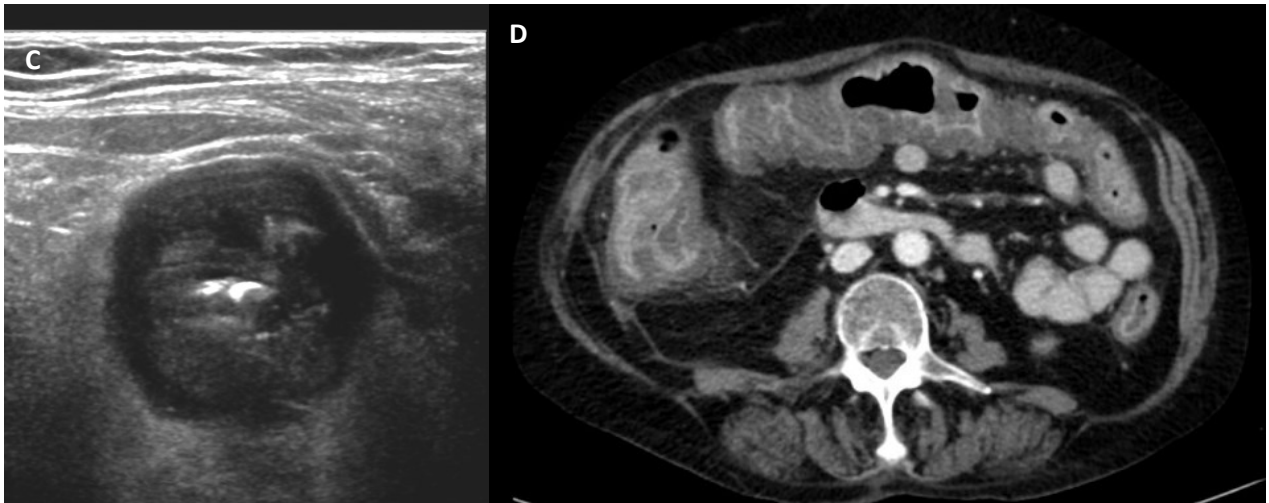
C – Bowel ultrasound, high-frequency linear probe. Clostridium colitis – thickening and edema of the large intestine wall (layers of the wall are visible). Extensive thickening of the hypoechoic large bowel wall due to edema, edema causes blurring of wall layers (but are distinguishable). There is also edema of adjacent fat.
